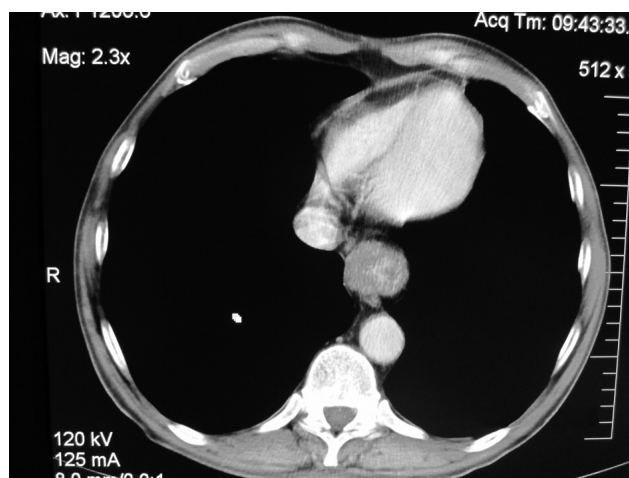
CT scan above the hiatal level shows massive infiltration of the esophageal wall
